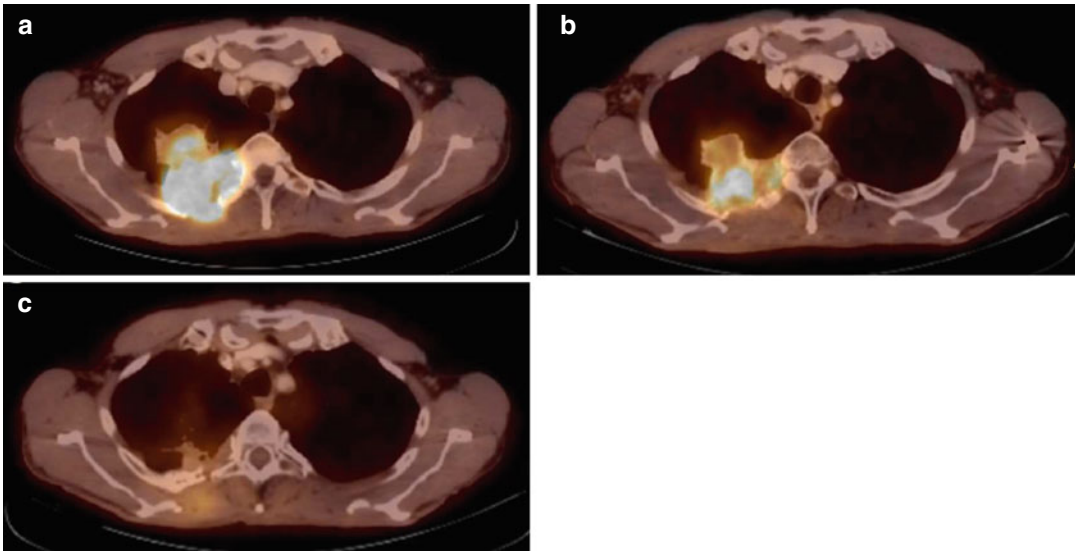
Early response FDG-PET/CT predicting late CT response in a patient with locally advanced NSCLC. (a) Axial fused FDG-PET/CT depicting the large tumor invading the thoracic wall before radiochemotherapy. (b) Corresponding slice of FDG-PET/CT 2 weeks after start
